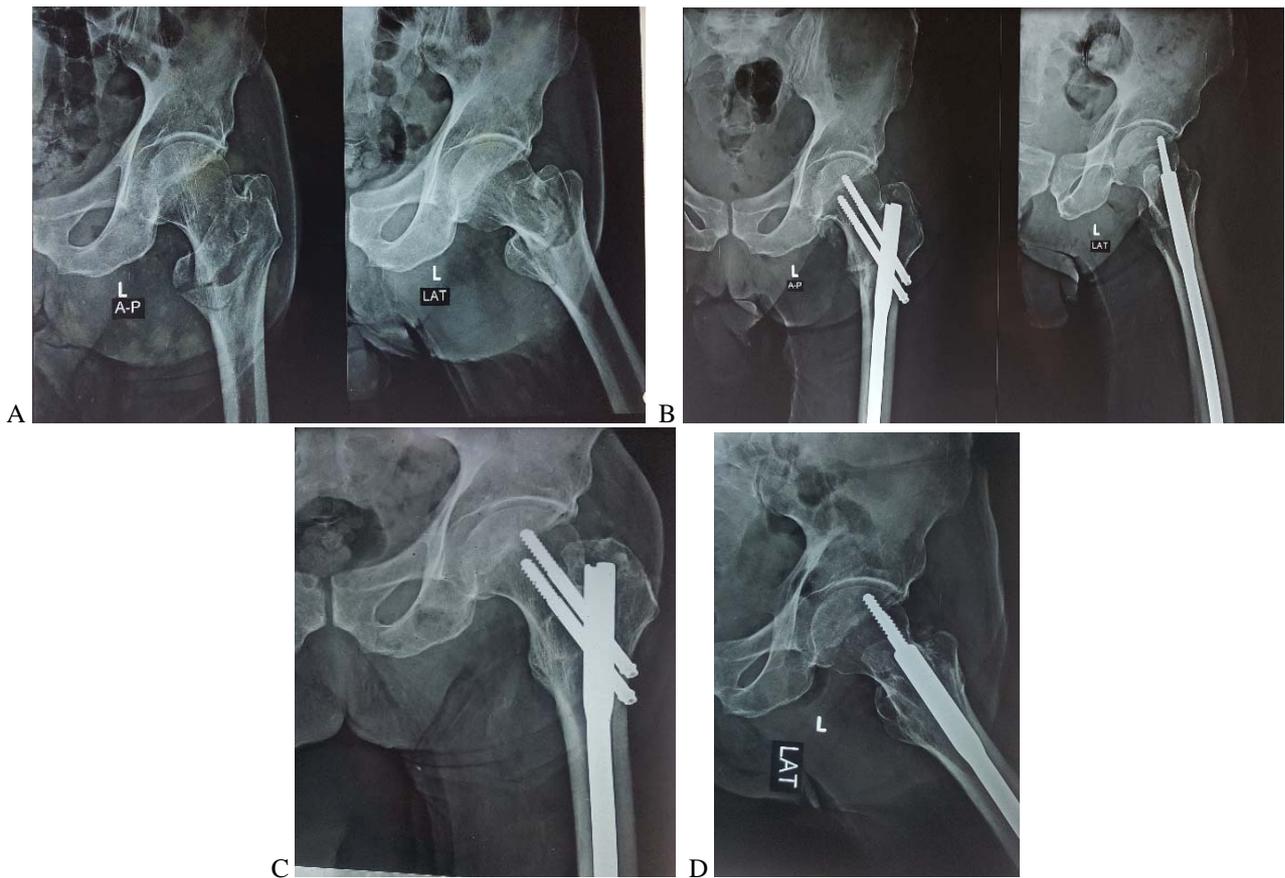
a: Preoperative AP and lateral x-ray showing trochanteric fracture (left side) B: Postoperative AP and lateral X-rays showing internal fixation by ATN C: AP view after two years. D: Lateral view after two years
